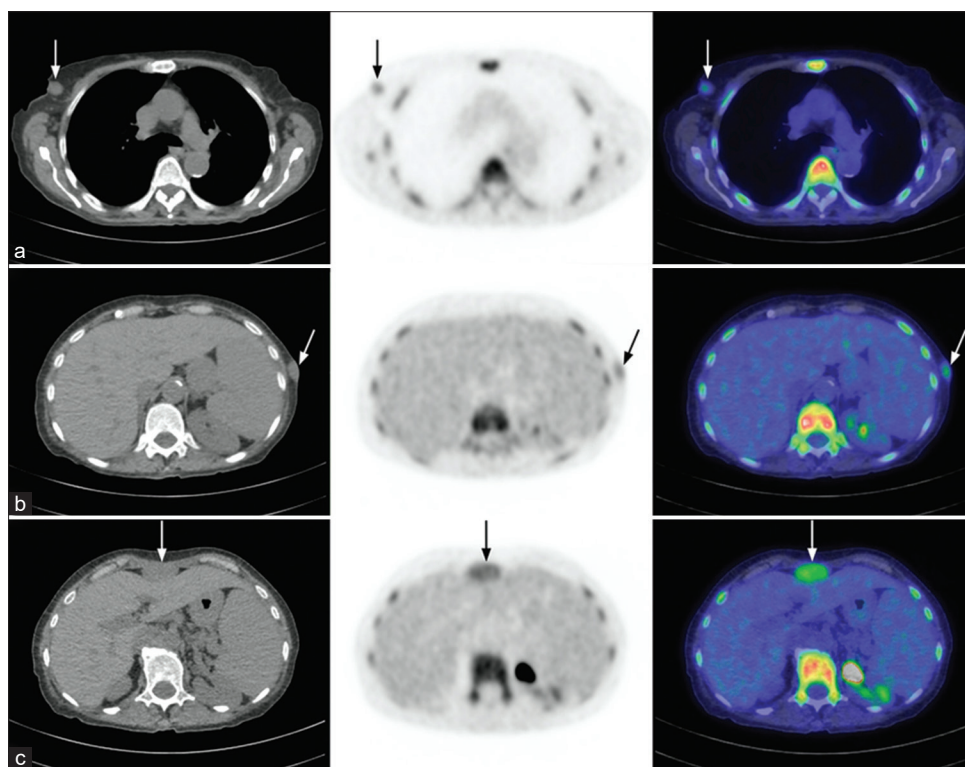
Axial images of the new subcutaneous lesion in the right anterolateral chest wall (row a), left lateral chest wall (row b), and anterior midabdominal wall (row c) demonstrated on computed tomography, positron emission tomography, and fused positron emission tomography/computed tomography
